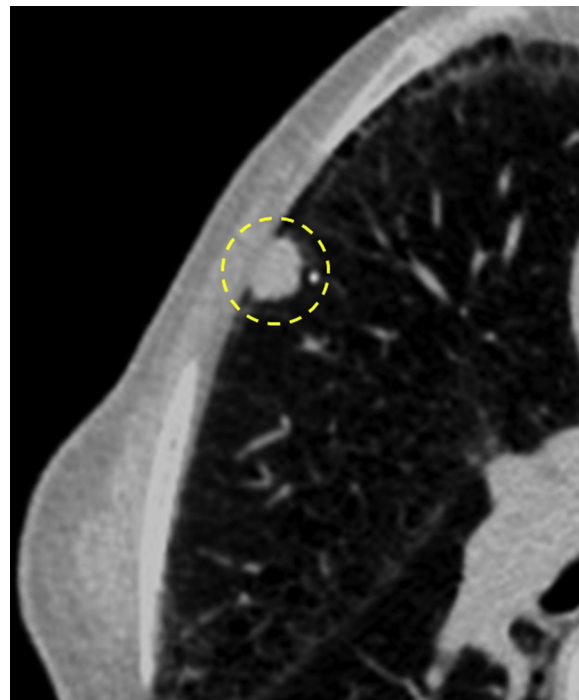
CT of the chest with right upper lobe peripheral pulmonary nodule (yellow hatched circle). Image reproduced with the patient's permission.
